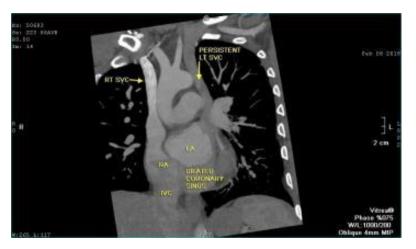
multi-slice CT, showing persistent left superior vena cava running along the left cardiac border of the heart into the dilated CS
